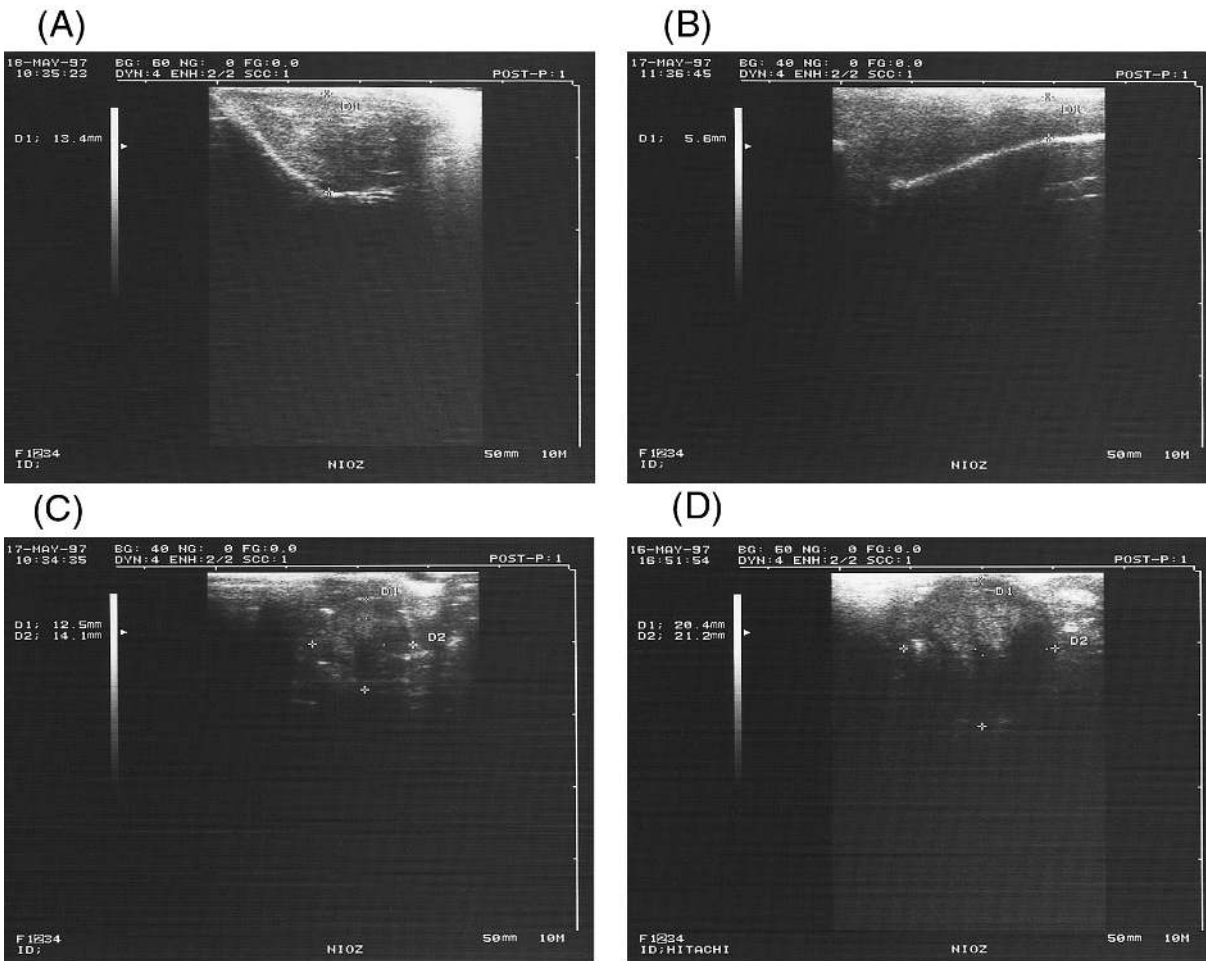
Examples of ultrasound images. *A*, Example of the ultrasonographic image of the left pectoral muscle from the transversal location in knots (the right side of the image is the direction of the shoulder). *B*, Example of the ultrasonographic image of the pectoral muscles from the longitudinal location in knots. *C*, Example of the ultrasonographic image of a small stomach in knots. *D*, Example of the ultrasonographic image of a large stomach in knots. Note that printing always yields a lower-quality image than the screen.
